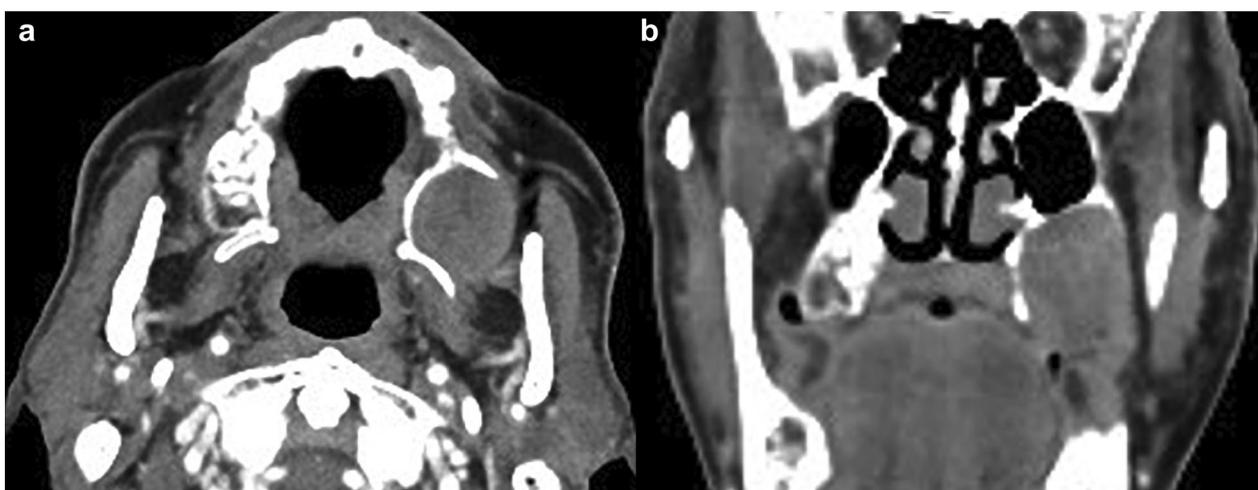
Images of case 3. Tumor fills the left maxillary sinus. a Horizontal section of computed tomography, b coronal section of computed tomography
